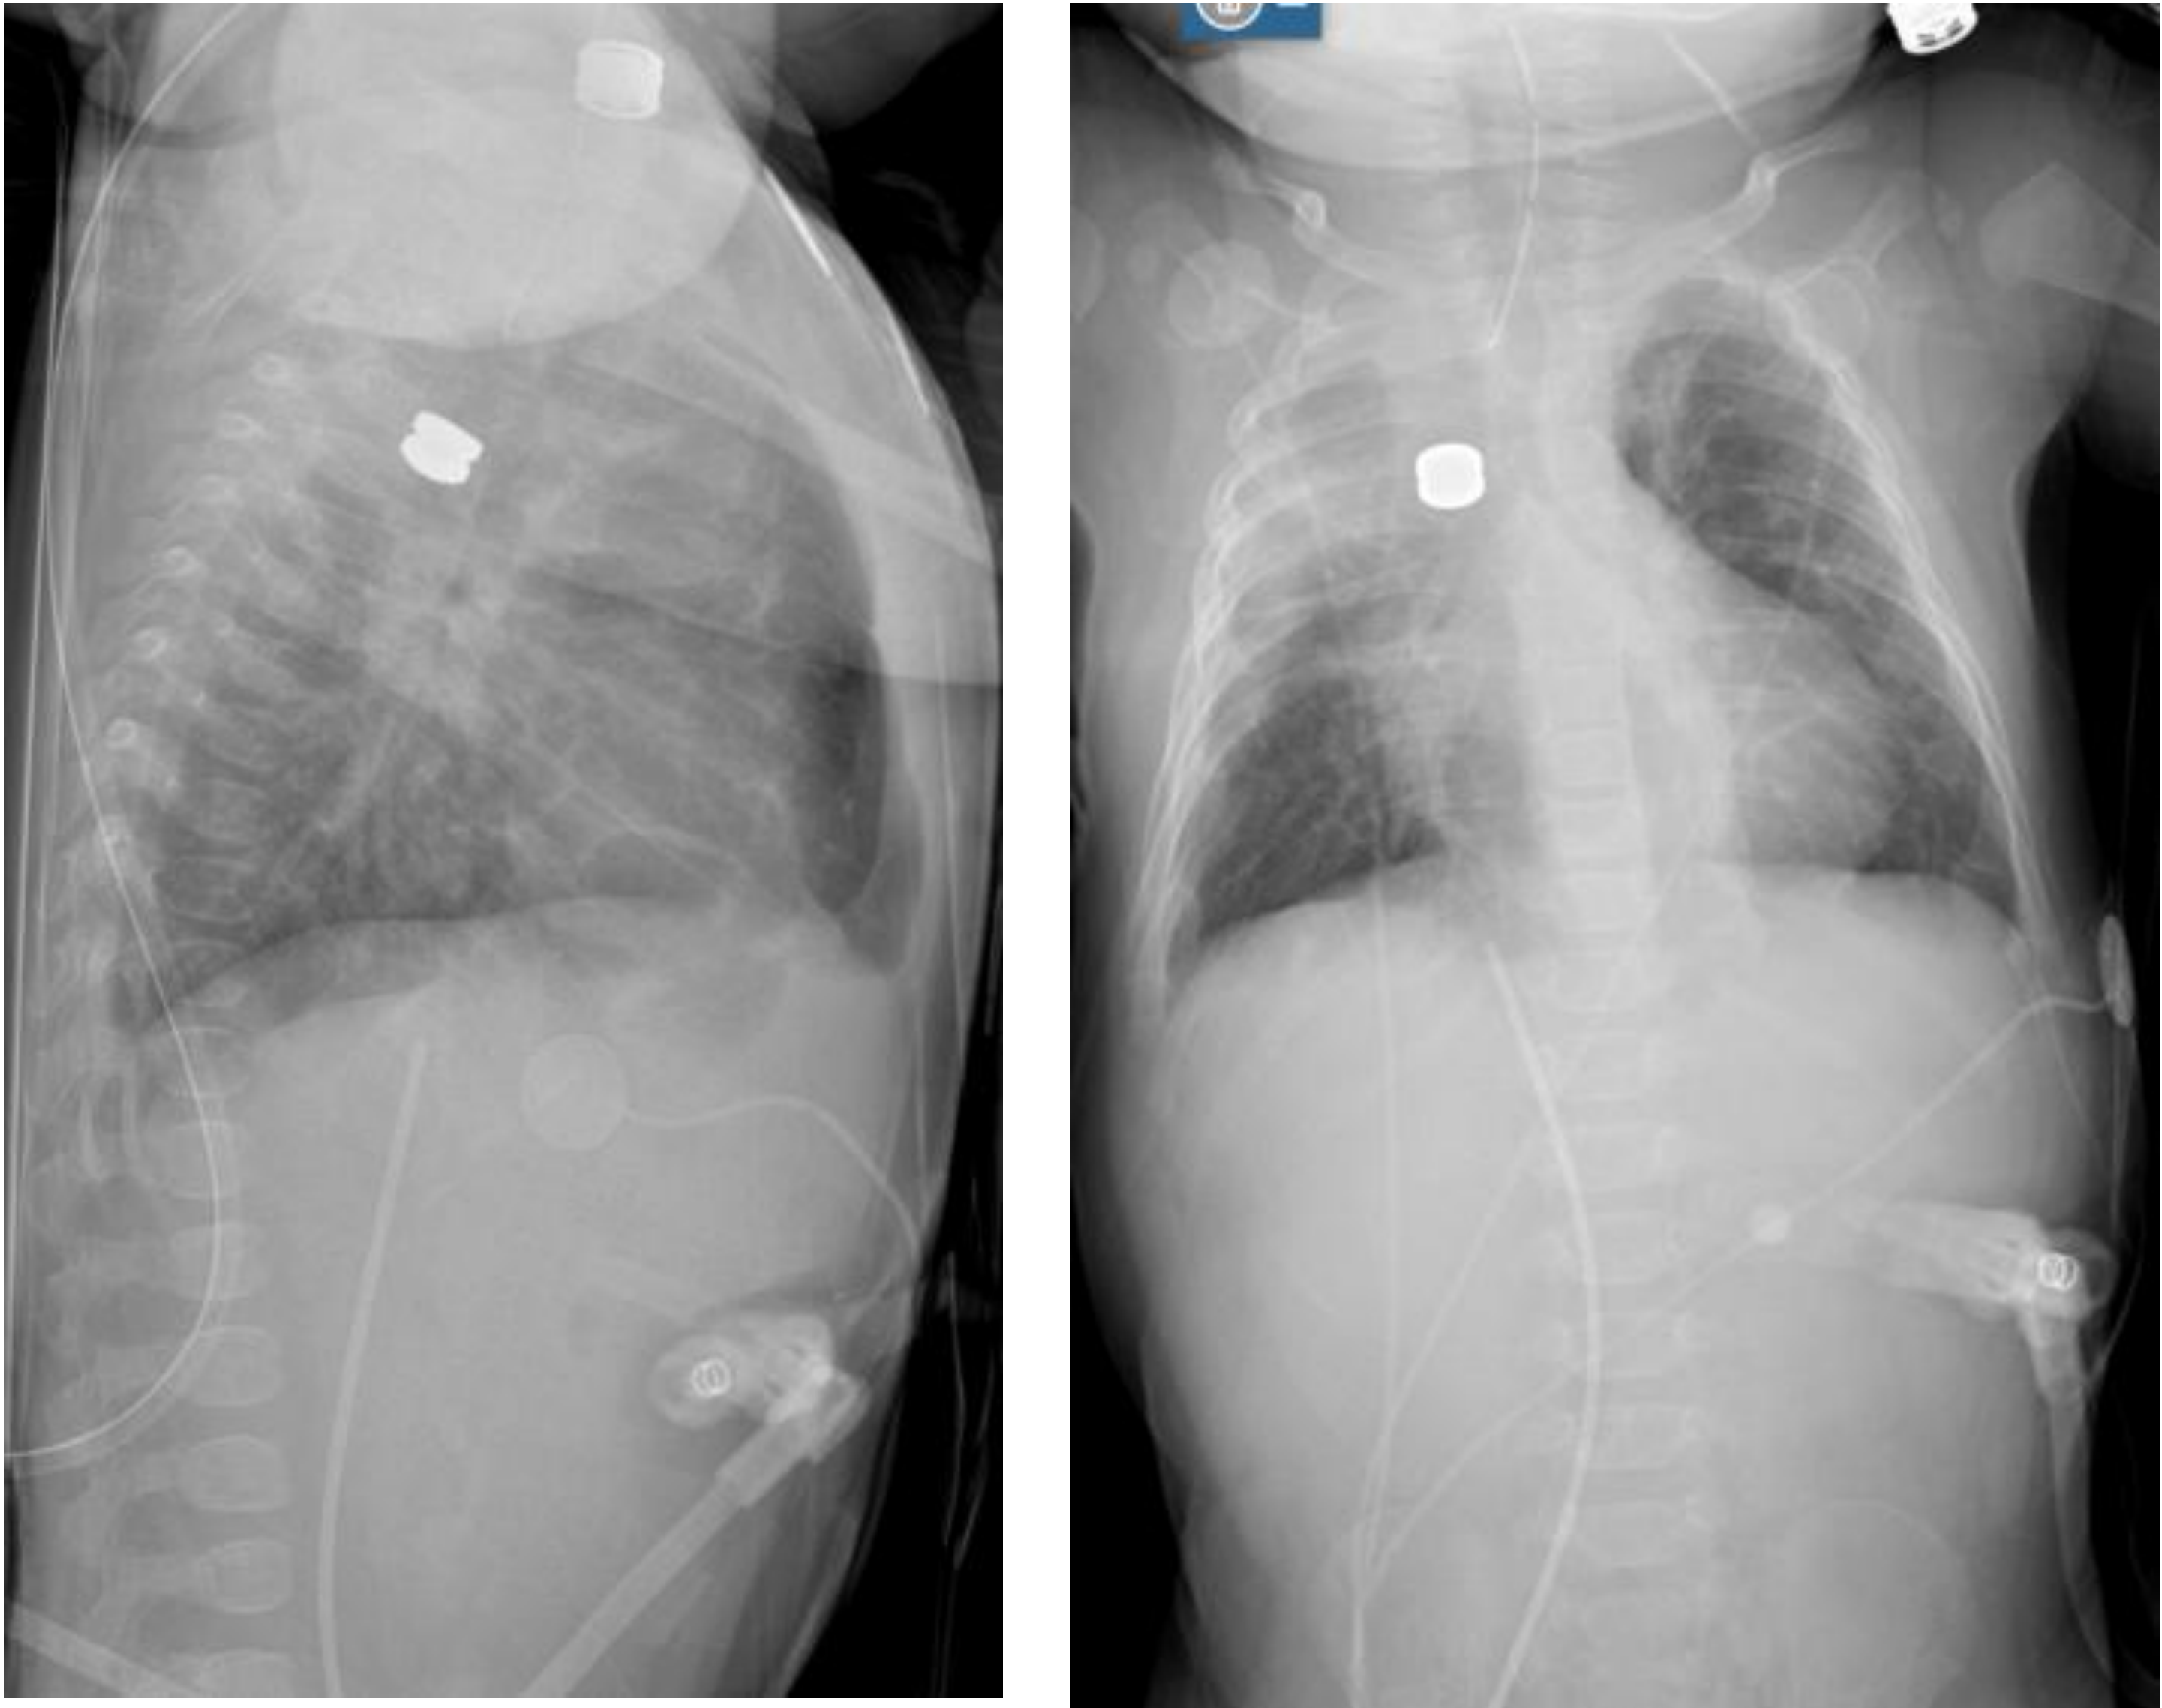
Radiographs of a patient with magnets in situ, lateral view on the left, anteroposterior view on the right. The upper magnet is placed endoscopically via the pharynx, the lower magnet is placed endoscopically via the gastrostomy. It usually takes about 8 to 12 days for the anastomosis to form. The magnets generally pass distally with peristalsis and are eliminated in the stool.
